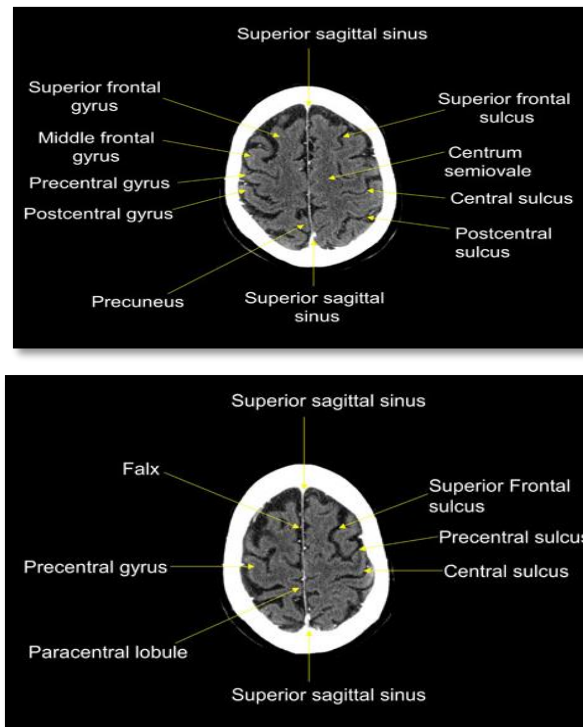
axial CT sections above the level of lateral ventricles (Nolte & John, 2002).
